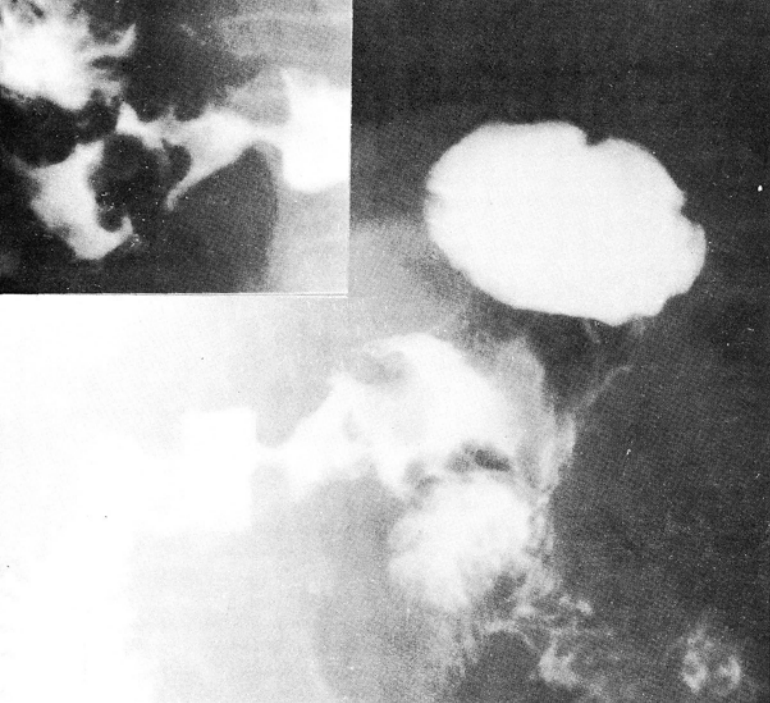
Contrast roentgenogram and spot film (insert) showing polypoid lesion in the region of the gastric antrum.
